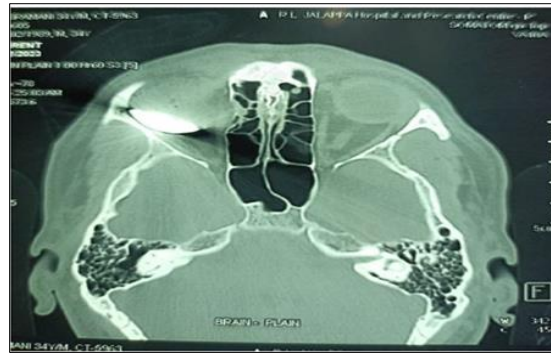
Axial CT image showing right intraocular foreign body
